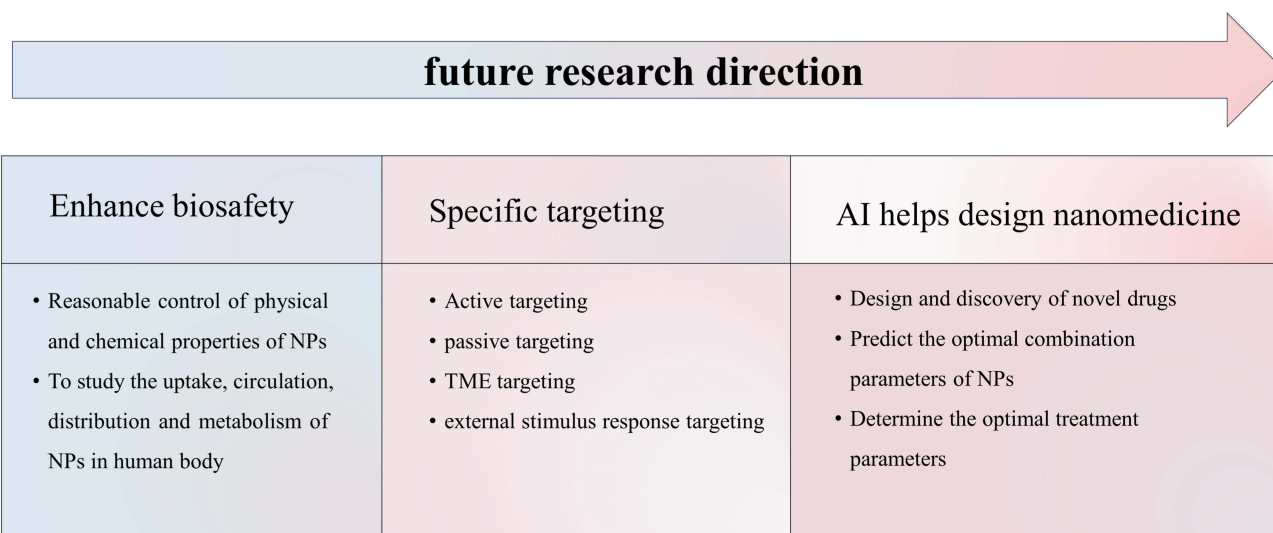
Future research directions for MRI-based nanotheranostic agents.
